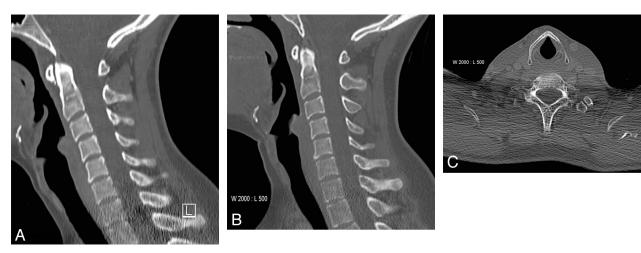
42-year-old male patient with follow-up neck CT for lymphoma at 70 kVp (A) and corresponding previous CT at 120 kVp (B). Sagittal reconstructions of the cervical spine demonstrate more image noise in the lower spine at 70 kVp in comparison to 120 kVp. Corresponding axial images through the lower neck (level of C7) at 70 kVp (C).
